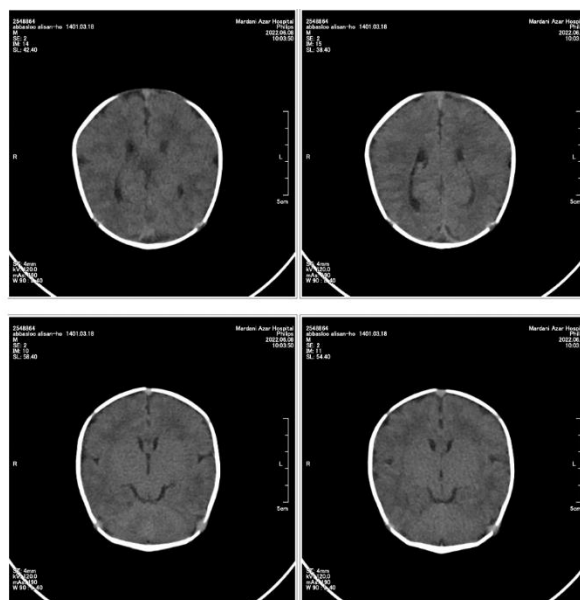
brain CT of our patient which shows evidence of HIE.
